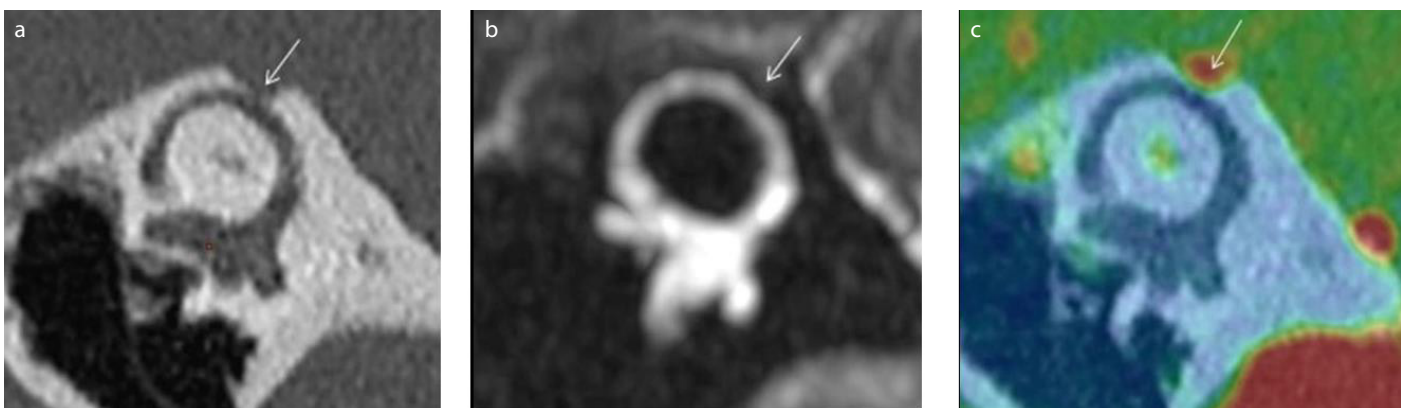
a-c. Case report 2 – Class B. a) right ear high-resolution computed tomography (HRCT) Pöschl plane. “Cookie bite” aspect. b) T2 HR FIESTA sequence: vascular structure (arrow) in contact with the membranous SSC. c) Fusion between HRCT and 3D T1 weighted enhanced sequences: limited contact between superior petrosal sinus (SPS) (arrow) and membranous superior semicircular canal, without evident labyrinthine compression.
